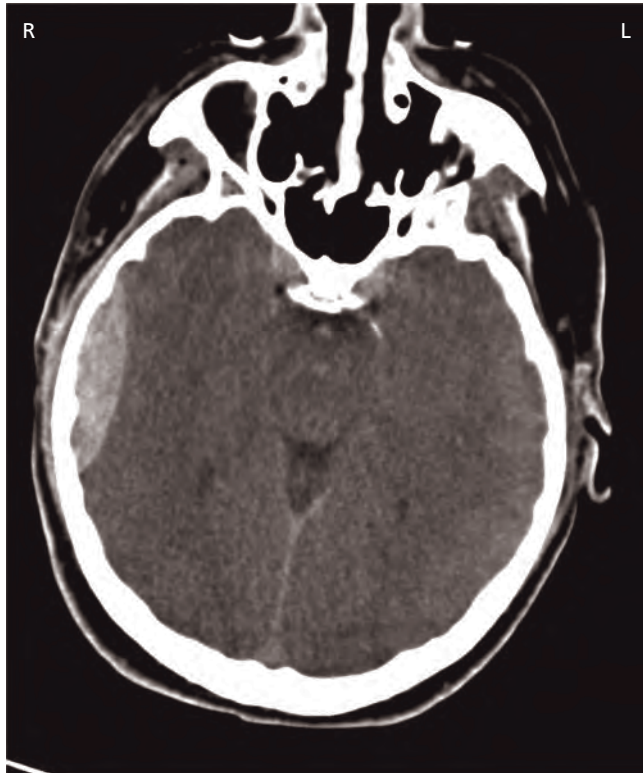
CT scan showing acute extradural haematoma.
